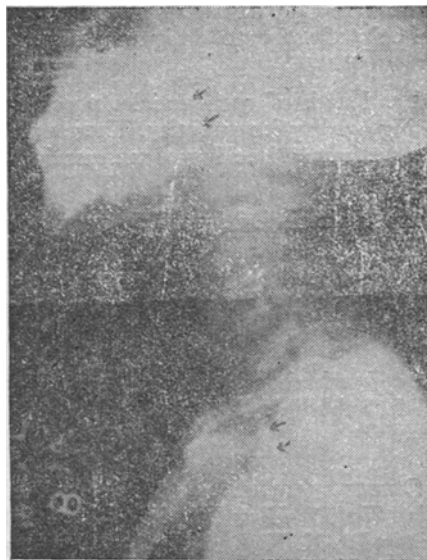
X-ray of the soft tissue of the neck, with dye in the nose. Arrow mark showing easy passage of the dye from the nose into the pharynx and oesophagus (After operation).
